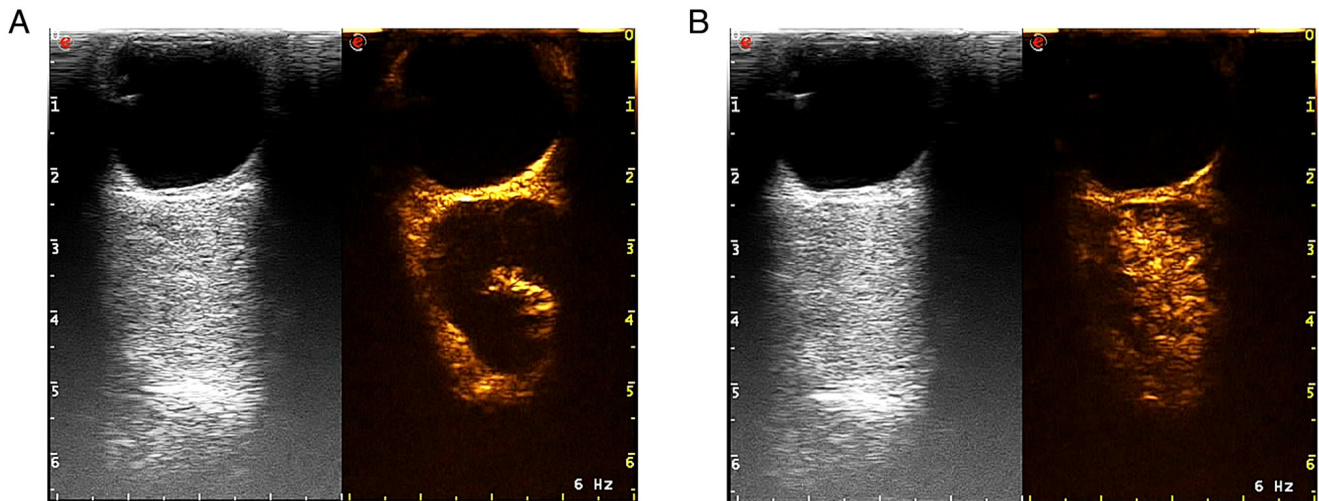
Images showing the typical progressive enhancement pattern of orbital cavernous venous malformation in a 44-year-old male patient with cavernous malformation. (A) Internal nodular enhancement of the lesion in 31 sec. (B) Progressive fill-in and eventually incomplete enhancement in 120 sec. The gray image is a conventional ultrasound image and the golden image is a contrast-enhanced ultrasound image.
